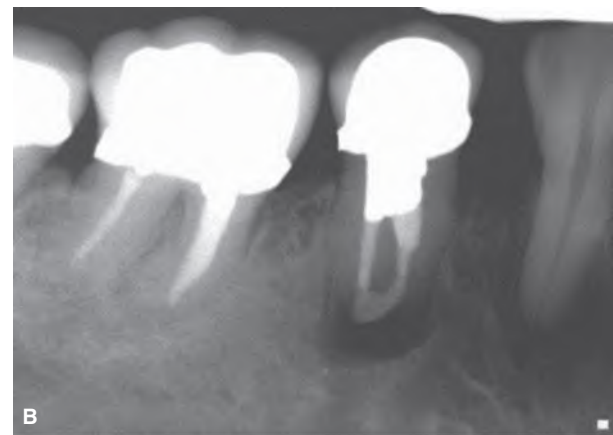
A. Proximity of the apex of the mandibular first premolar to the neurovascular bundle can be a contraindication for periapical surgery, and B. It requires caution and skill if surgical endodontics is performed. (Courtesy of Dr. Tory Silvestrin, Loma Linda, California, U.S.A.)
